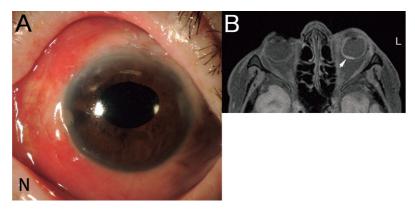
A, Scleritis recurred in the nasal region (N) 6 months after the resolution of the scleritis in the temporal region. The choroid could be seen through the sclera in the temporal region due to scleral thinning; B, a T2-weighted MR image showed thickening and high intensity in the nasal part of the wall of the left eye (white arrow), indicating a recurrence of scleritis in a different region from the primary lesion. The partial defect of the right eyelid is an artifact.
